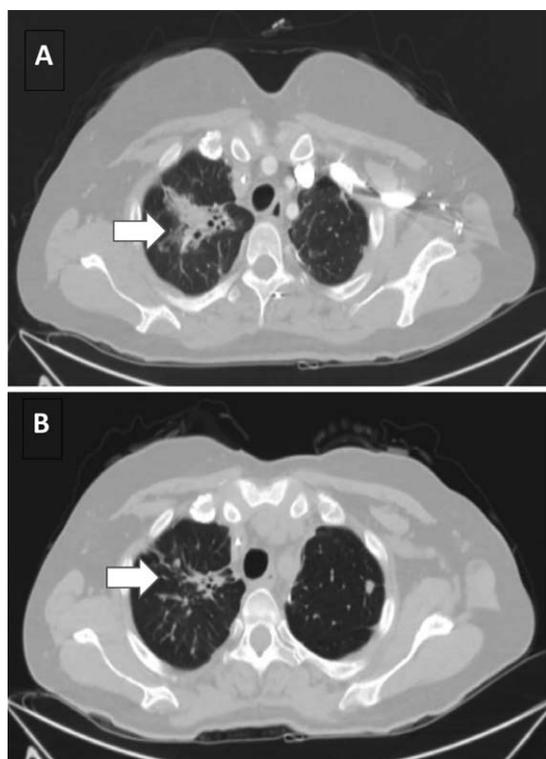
Response of an *ERBB2*-amplified metastatic colorectal cancer (mCRC) to antihuman epidermal growth factor receptor 2 (HER2)-targeted therapy. A 39-year-old woman with a pT3N0 rectal adenocarcinoma developed widespread metastatic disease and was treated with systemic chemotherapy and metastasectomies. The mCRC was found to be *KRAS* wild-type on routine single-gene testing and anti-EGFR therapy with cetuximab was used until disease progression. Comprehensive genomic profiling was performed on a metastasis sample at that time and revealed *ERBB2* amplification at 21 copies and a tumor protein p53 (*TP53*) base substitution. Combination therapy with trastuzumab with a backbone of capecitabine and oxaliplatin was initiated. Treatment with trastuzumab continued for 12 months, after which time the patient's symptoms returned with biomarkers and radiology confirming progressive disease. Representative computed tomography scan image of upper lung metastasis is shown (A) at baseline and (B) after 3 months of trastuzumab and chemotherapy. The arrow indicates significantly regressed tumor burden accounting for improved pulmonary symptoms. The targeted therapy using trastuzumab in combination with cytotoxic chemotherapy maintained a strong response in the patient over a 1-year course of therapy, reducing tumor burden and improving quality of life.
